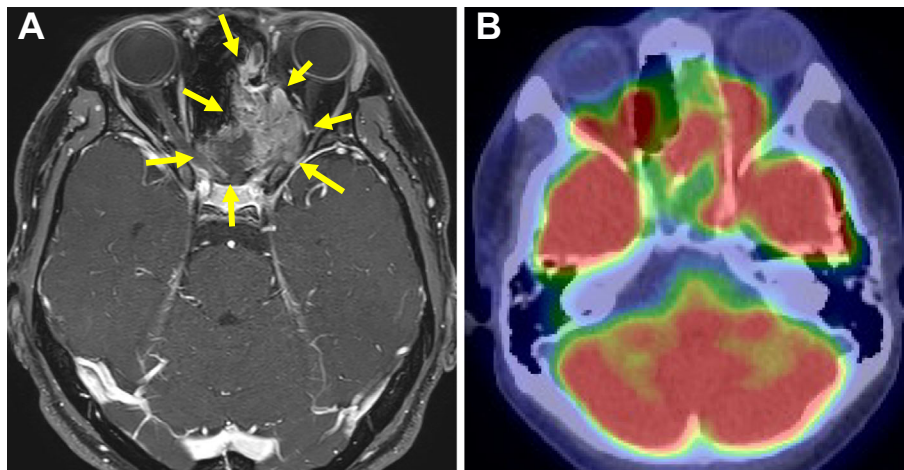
Magnetic resonance imaging (MRI) revealed a left posterior ethmoid sinus mass (A, arrows), and positron emission tomography (PET)-computed tomography (CT) revealed a mass that showed an increased ^{18}F -fluorodeoxyglucose (FDG) uptake (B).
